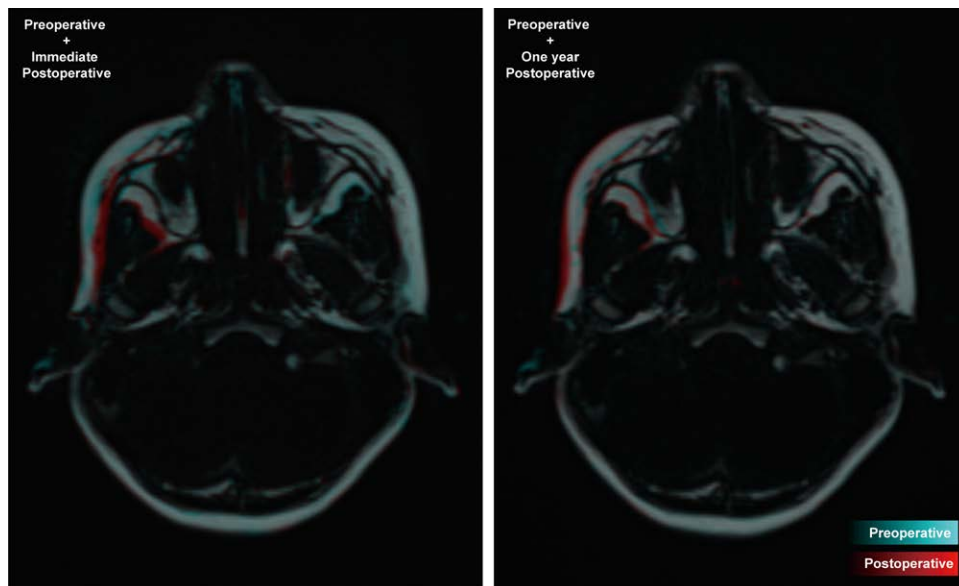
Fused MRI scans (patient 16, middle face) show the reconstruction of the deep fat compartments with long-term stable results.
